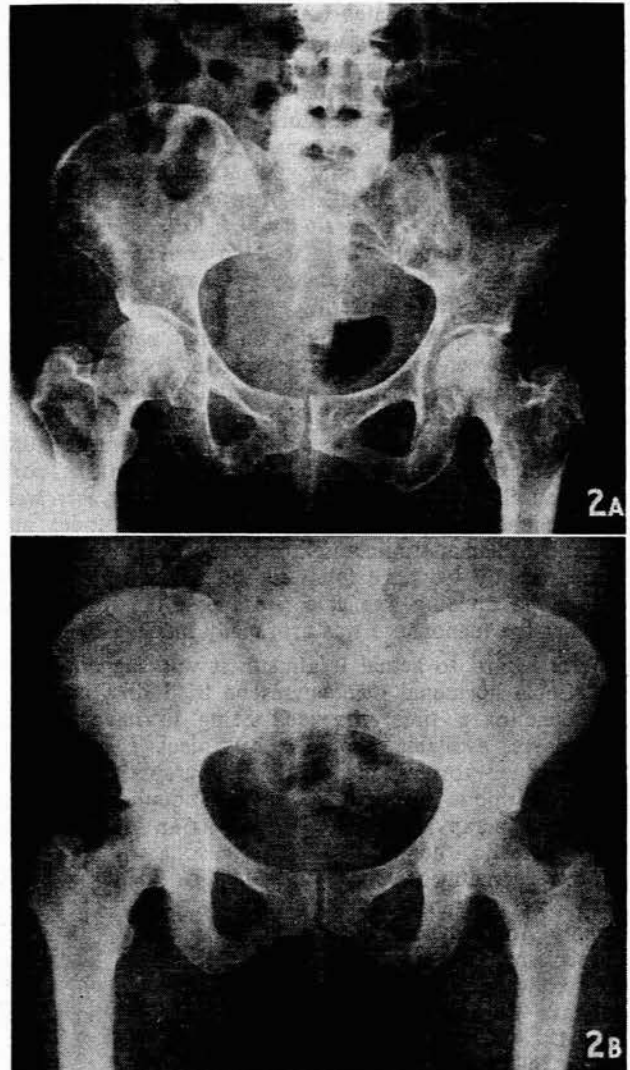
Patient with widespread bony metastases. A. X-ray of pelvis in February 1958, showing extensive osteolytic metastases. B. X-ray of pelvis 6 months after oophorectomy showing the remarkable improvement.
